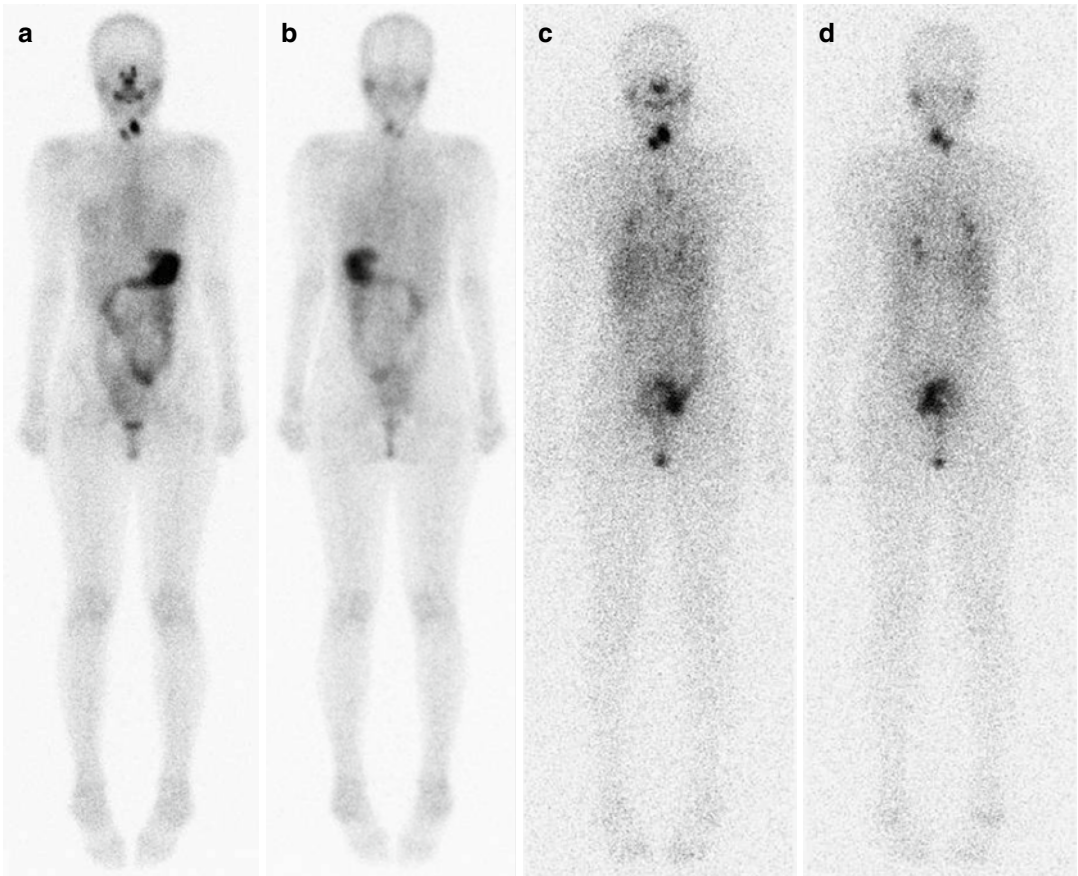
Diagnostic and post-therapy whole body scintigraphy for metastatic thyroid cancer. A 15-year-old girl with papillary thyroid cancer underwent near-total surgical thyroidectomy, which showed disease involvement in multiple cervical lymph nodes. Six weeks later, diagnostic whole body scintigraphy was performed with ^{123}I . Images acquired in the anterior (a) and posterior (b) projections show physiological tracer accumulation is seen in the lacrimal glands and nasal secretions, salivary glands and oral secretions, breasts, stomach, bowel, and bladder. Focal uptake on each side of the thyroid bed could represent remnant thyroid tissue or metastatic disease in cervical
